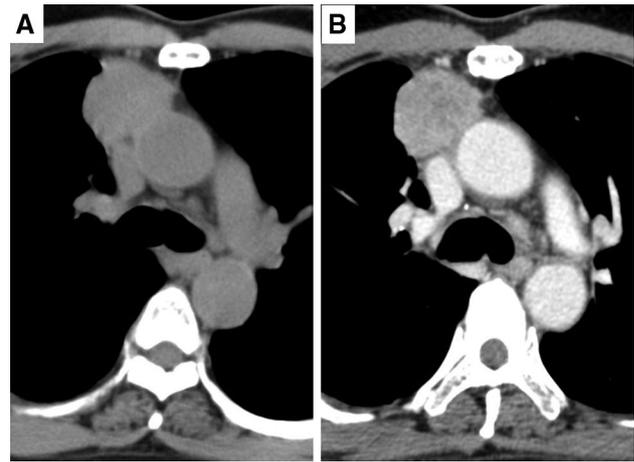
a, b Serial computed tomography images of a 66-year-old man with Masaoka–Koga stage III thymic squamous cell carcinoma. The maximum tumor size increased from 4.1 to 4.4 cm over 86 days. The tumor doubling time of this tumor was therefore determined to be 213 days
